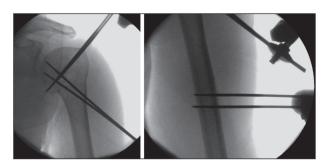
Intraoperative X-ray control.
